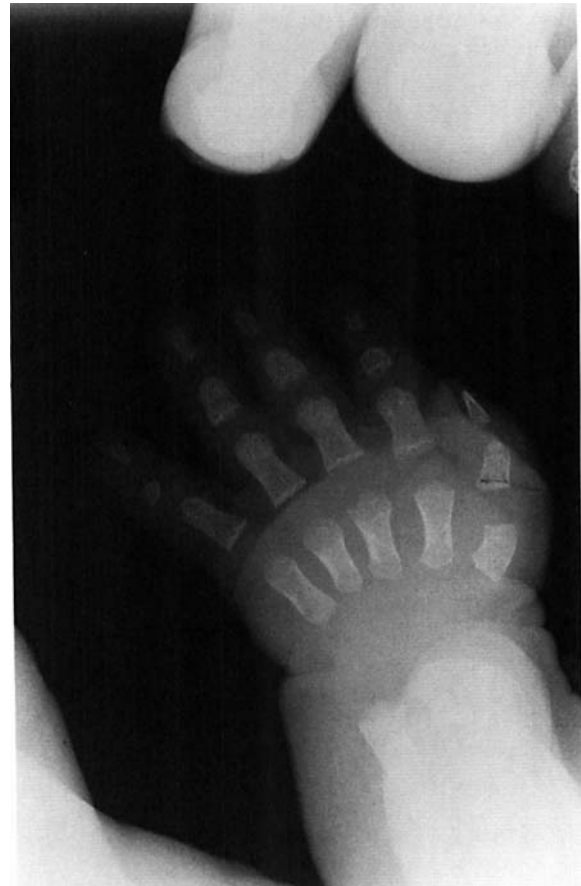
X-ray view of the left hand (age 9 months).
